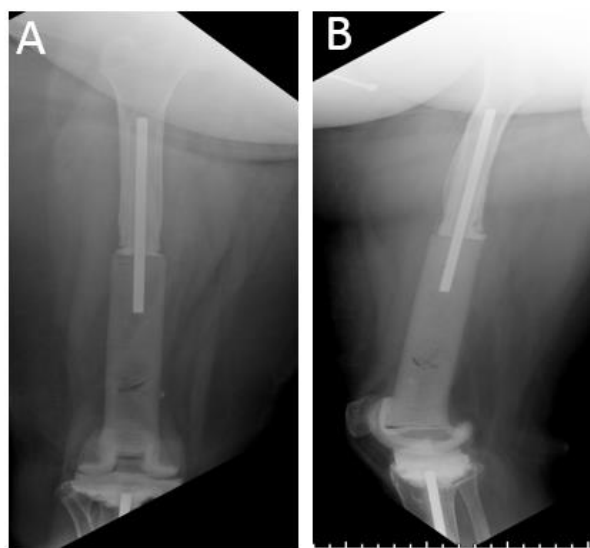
X-ray of right knee spacer
